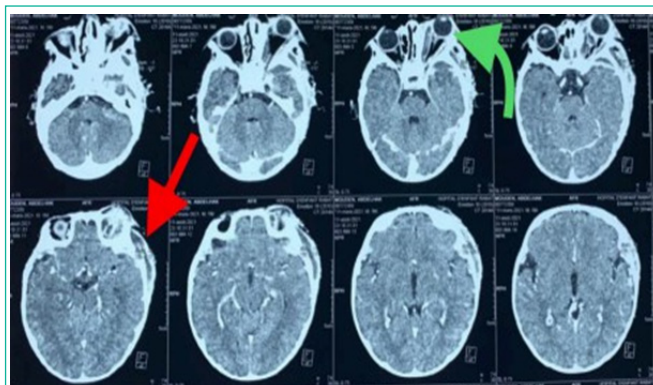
Axial views of a craniofacial CT scan showing a complete opacification and mucosal thickening of the left ethmoidal cells, a well-circumscribed hypodense collection in the left temporal subcutaneous and muscular planes, with features consistent with an organized abscess (red arrow) associated left-sided exophthalmos consistent with Chandler stage III orbital cellulitis (green arrow).
